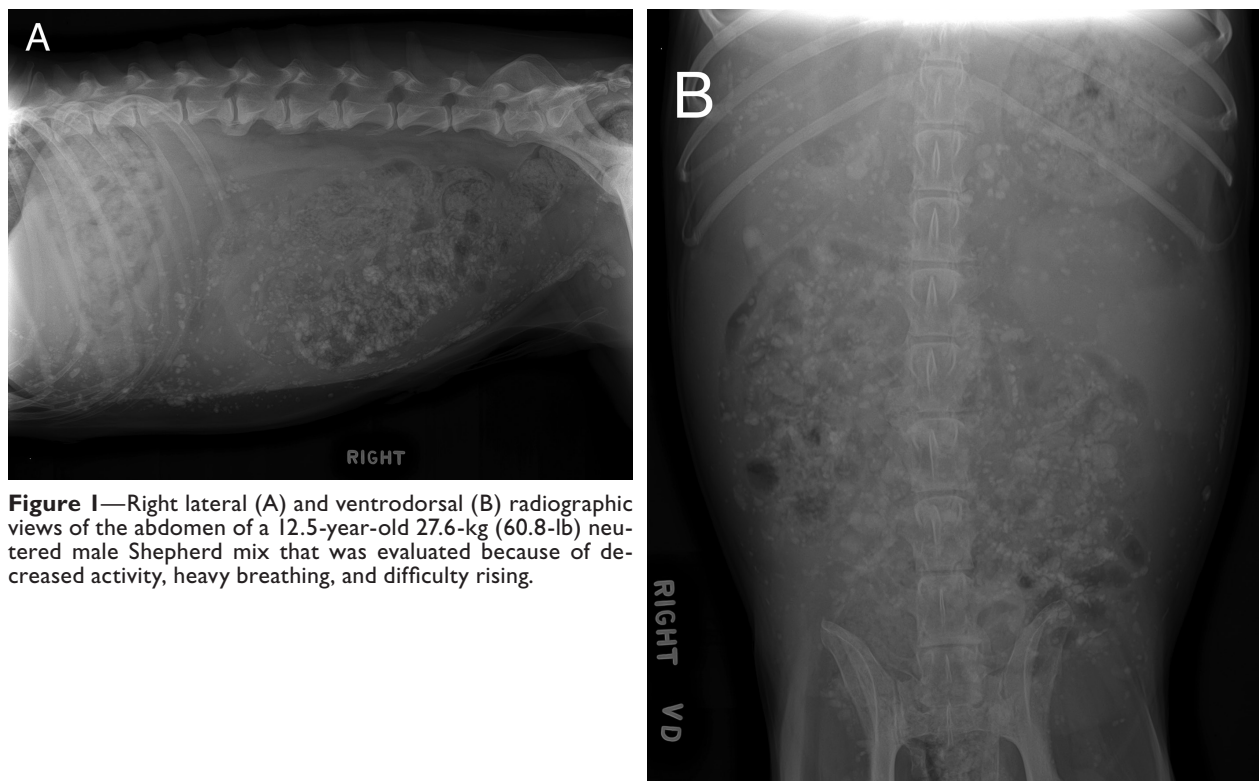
Right lateral (A) and ventrodorsal (B) radiographic views of the abdomen of a 12.5-year-old 27.6-kg (60.8-lb) neutered male Shepherd mix that was evaluated because of decreased activity, heavy breathing, and difficulty rising.
